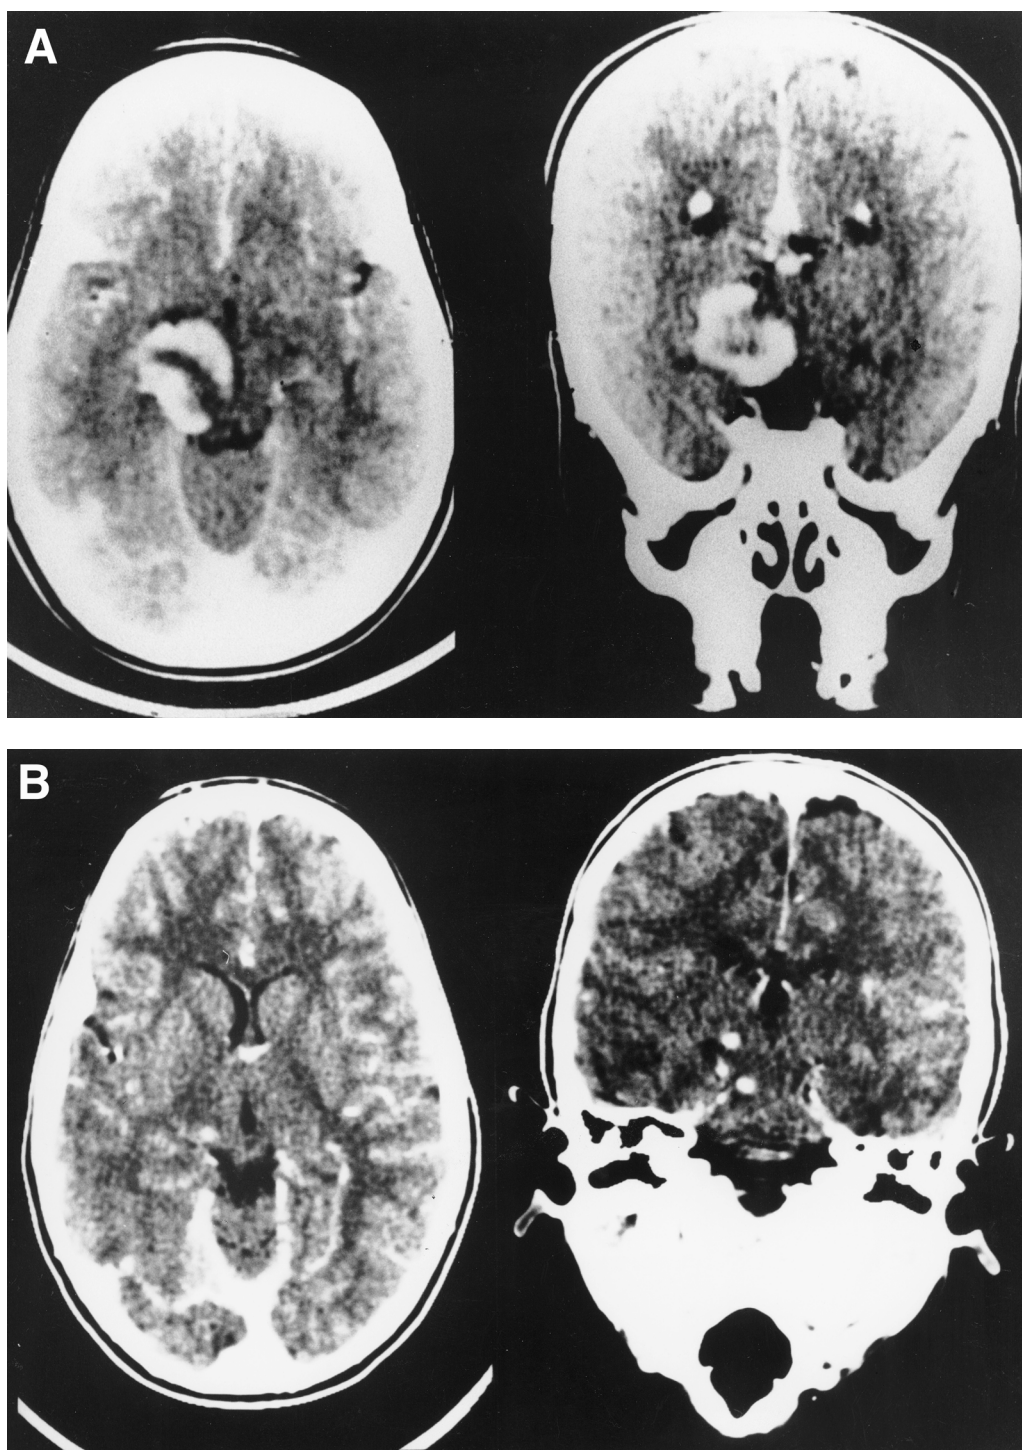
(A) Axial and coronal enhanced CT scans of 1-year-old child with focal low-grade midbrain astrocytoma before surgical resection. (B) Axial and coronal enhanced CT scan of same child 4 years after subtotal resection and a course of chemotherapy. The tumor shows a complete response.
